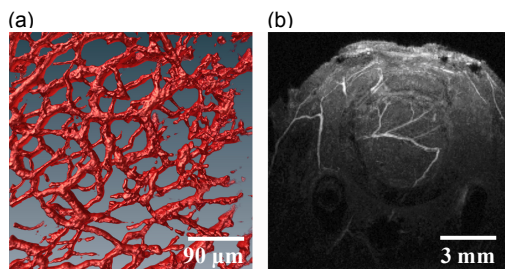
Vasculature in tumor tissue in a dorsal window chamber imaged by CLSM (a) and MRI (b) showing the difference in resolution for the two techniques
